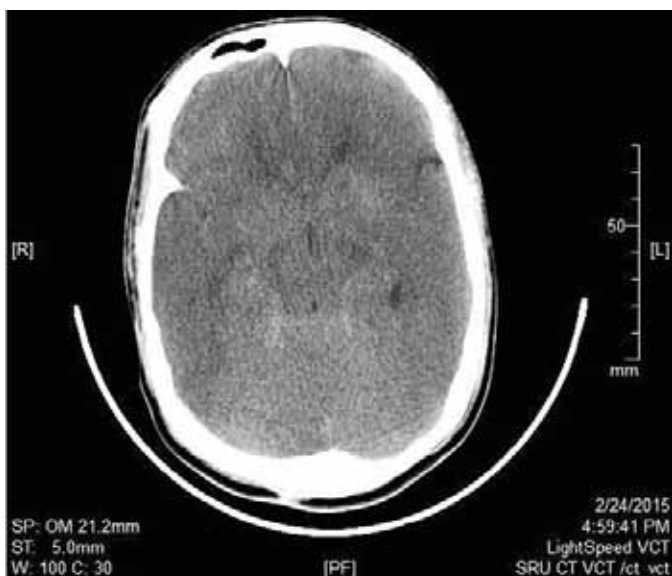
Computed tomography scan of brain (plain study) showing diffuse cerebral edema.
